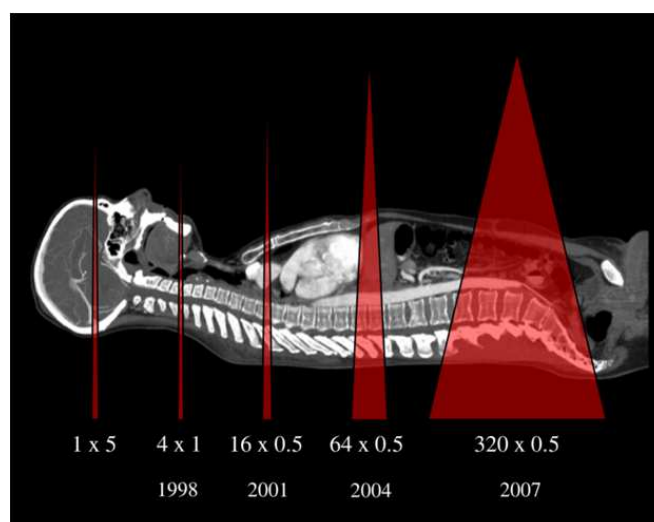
Evolution of the Z axis coverage since the beginning of multislice scanners to the introduction of the 320 detector-row cone-beam CT scanner.
